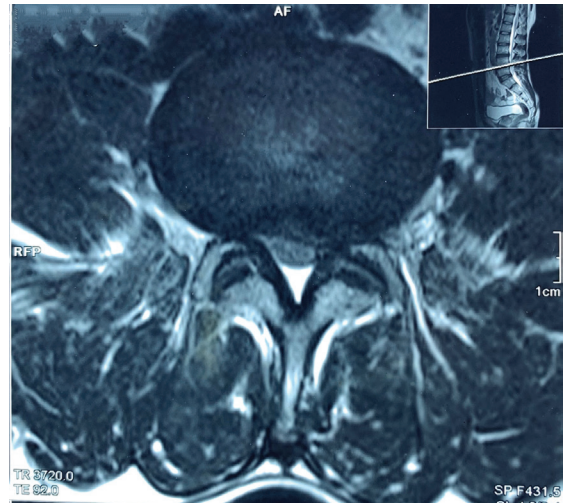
Axial T2-weighted MRI image of the Lumbar spine showing herniated disc on left L4/5 space
